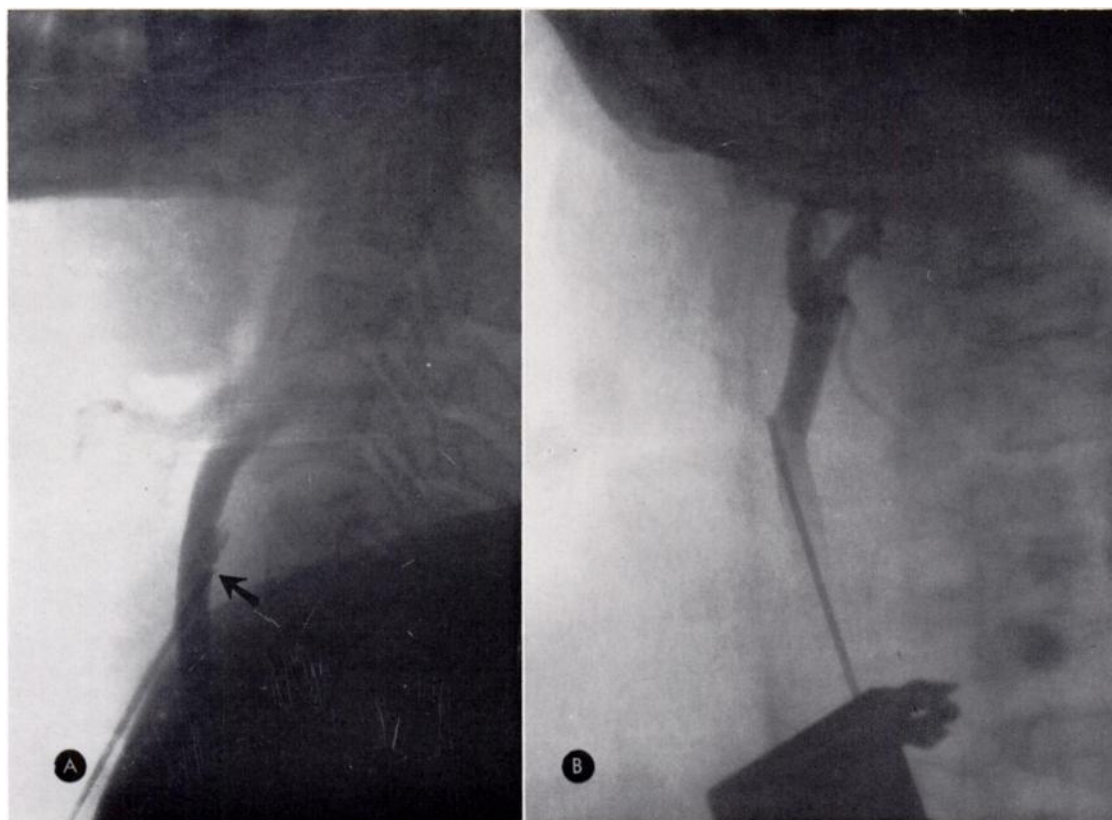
Polaroid roentgenograms of the neck after injection of 2 cc. of contrast medium. (A) Lateral roentgenogram showing that the point of the needle lies against the posterior wall of the common carotid artery (arrow). There is a small quantity of subintimal contrast medium. (B) Anteroposterior roentgenogram of another case showing that the needle is pressing against the lateral wall of the artery. The point of the needle was positioned more medially before the main injection was made.
